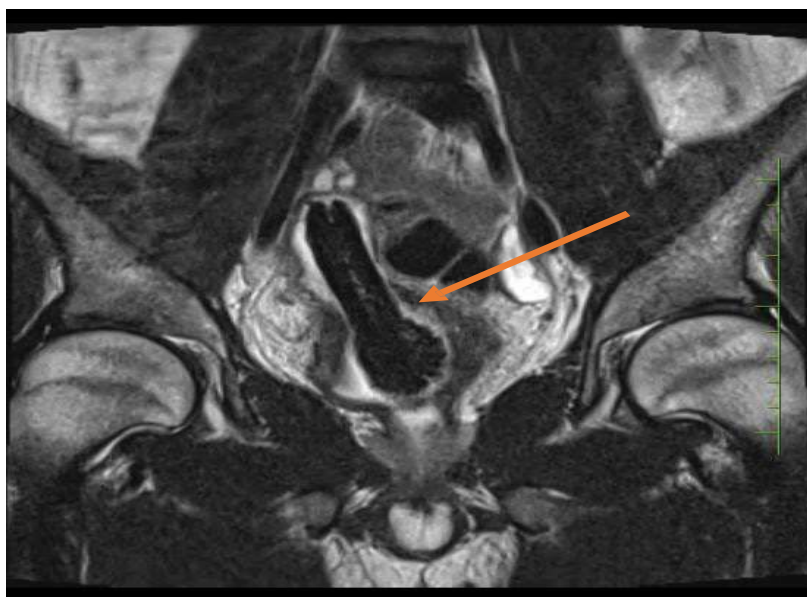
MRI showing elongated foreign body (Orange arrow)
